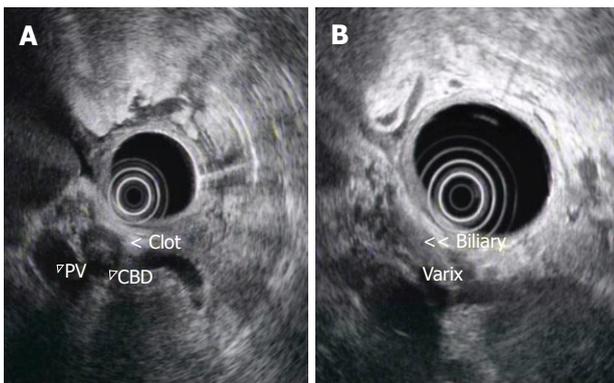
Endoscopic Ultrasound. A: Endoscopic ultrasound image showing the CBD was completely obstructed by the hypoechoic clot; B: Endoscopic ultrasound image showing multiple small anechoic tubular structures around the CBD, consistent with varices.
